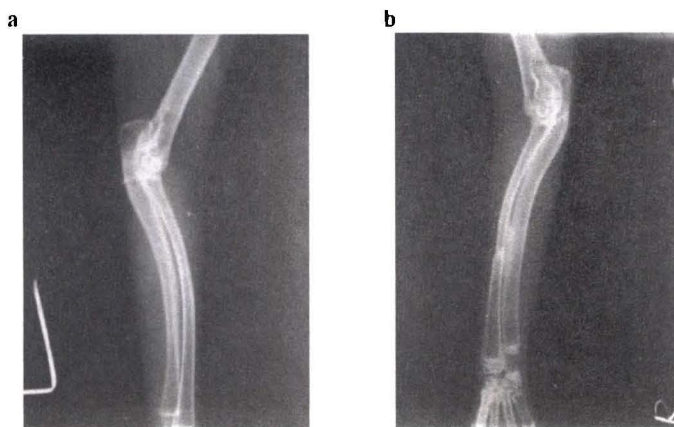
a) Anteroposterior radiograph of radial osteotomies at 8 weeks after bone marrow grafting. Note the healing and remodeling of fracture site completed. b) Lateral radiograph of radial osteotomies at eight weeks after saline injected on the other (right) forearm. Note. The healing and remodeling of fracture site was not completed
